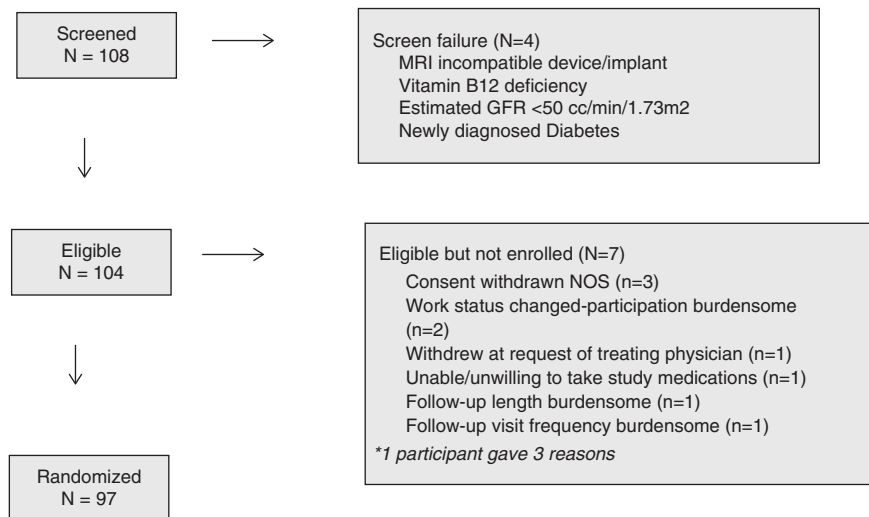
Flow of participants from screening to randomization. NOS, not otherwise specified; MRI, magnetic resonance imaging.
